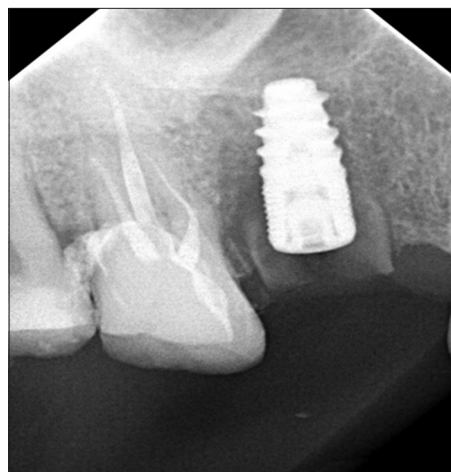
Periapical radiograph after the removal of the exposed parts of the fragments after 5 weeks
